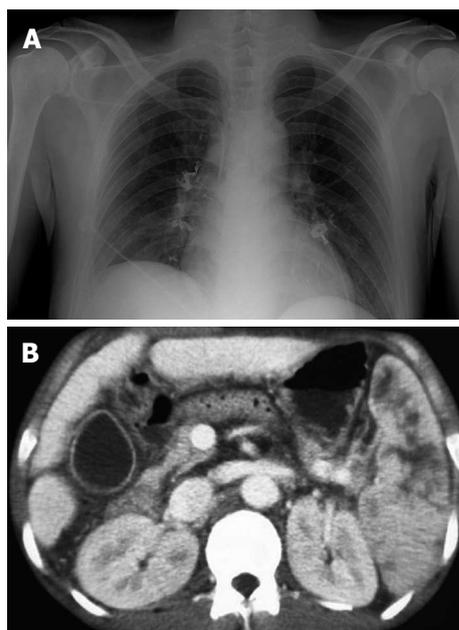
Embolic complications of Histoacryl® injection. A: Chest radiography showing pulmonary embolism after Histoacryl® injection; B: Computed tomography showing the presence of lipiodol in the splenic vein after Histoacryl® injection.
